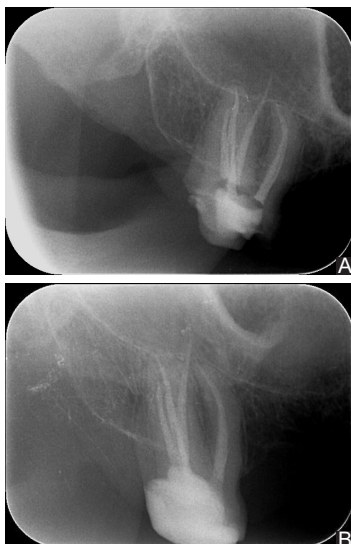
Working Length Radiography
